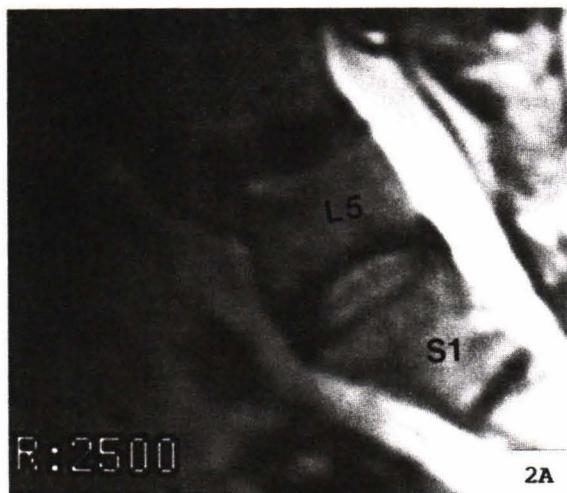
Conventional T2-weighted sagittal MR images demonstrate three types of disk, A) normal disk, B) mildly degenerative disk, and C) severely degenerative disk. The markedly decreased height of disk posteriorly in B) and C) resulting PDH to be less than ADH.
